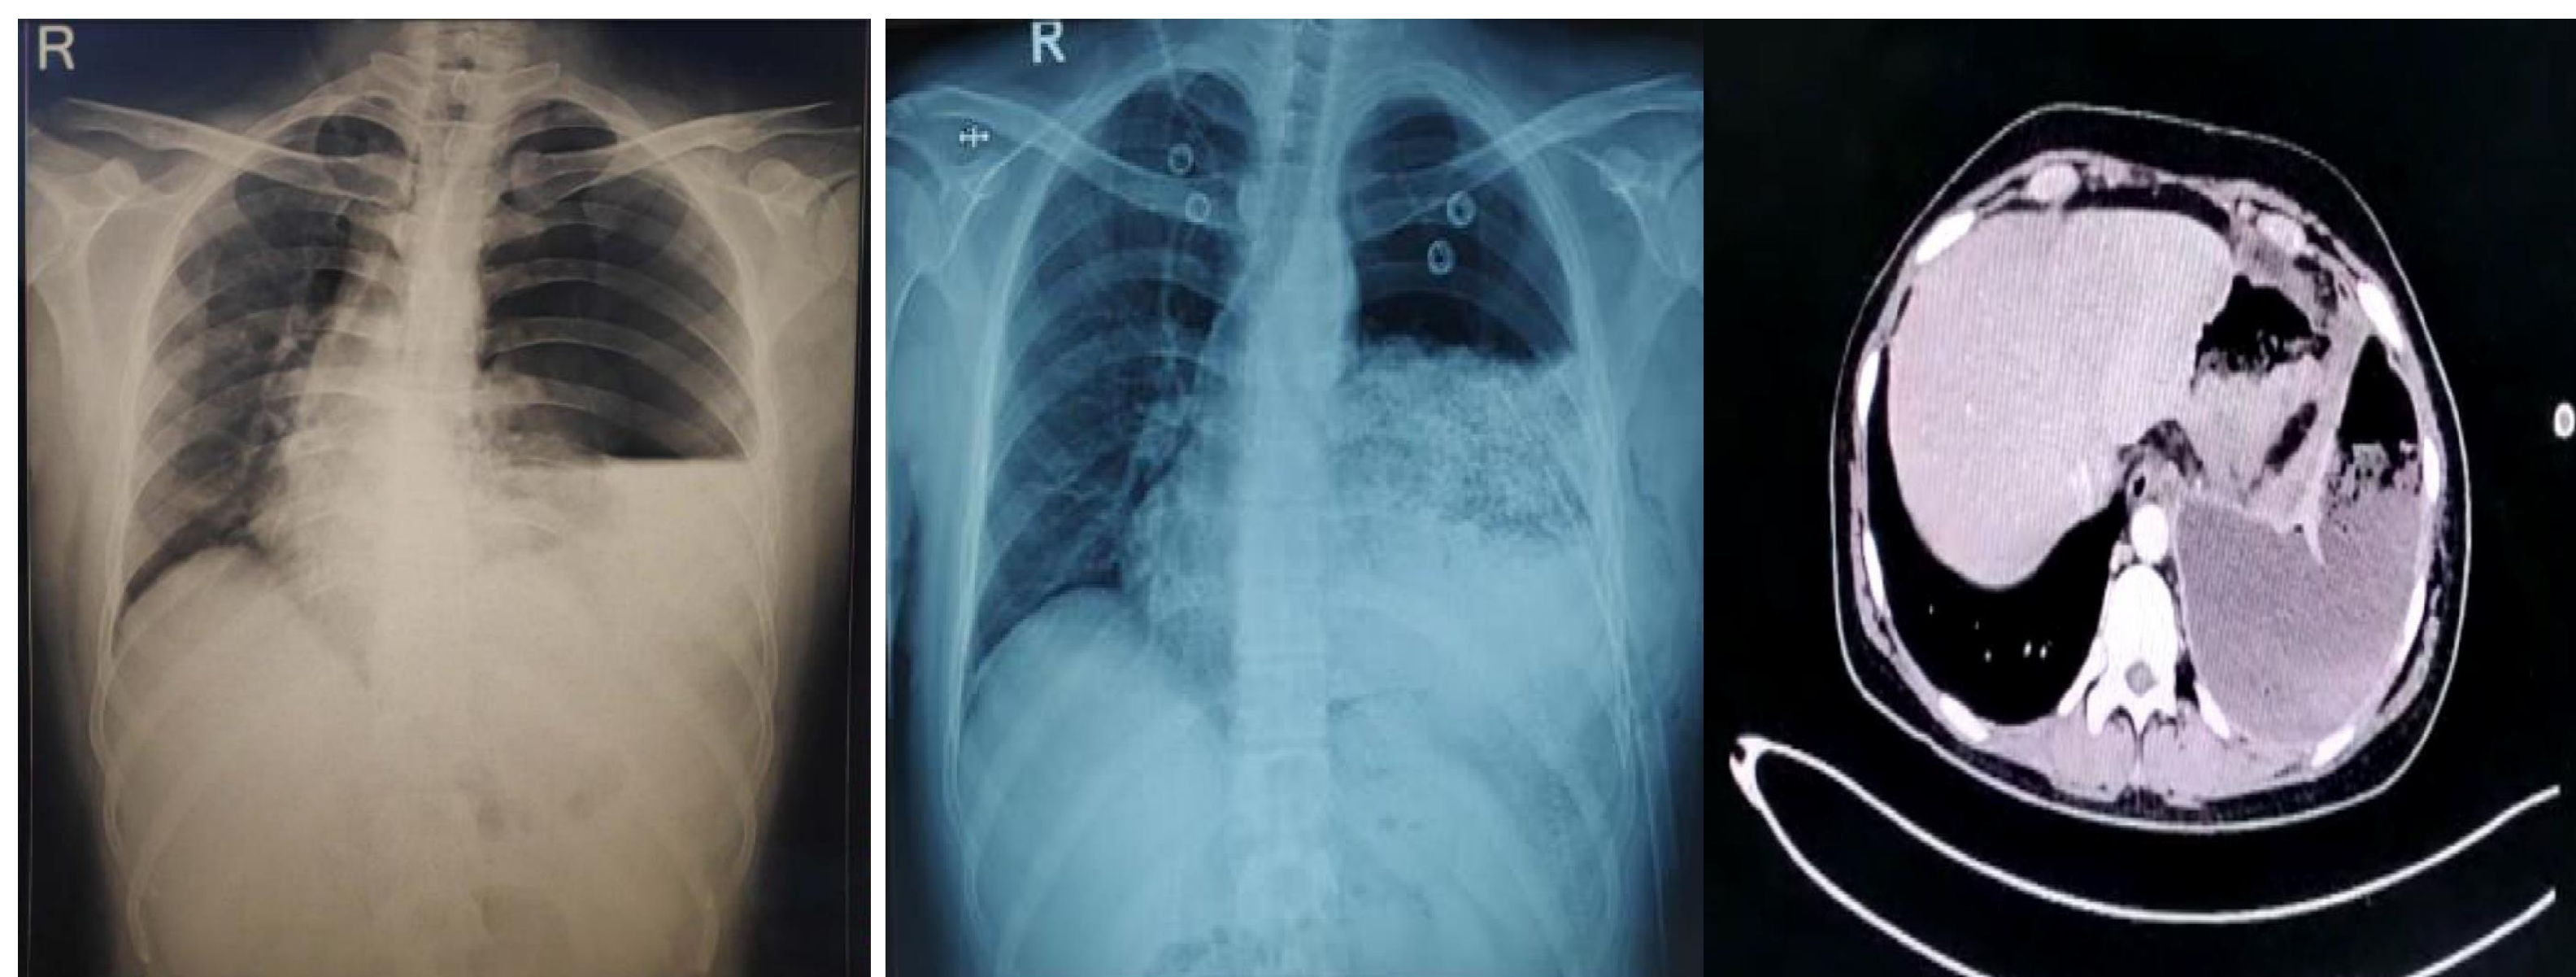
a) Chest x-ray on initial presentation ;fig b) Chest x-ray after ICD insertion
